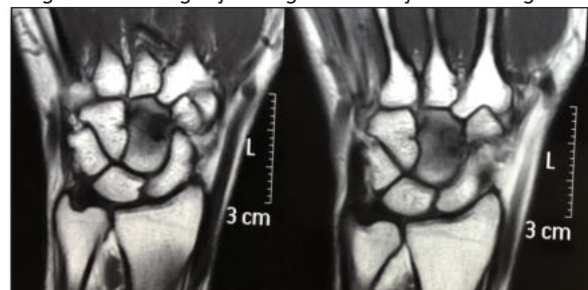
PRE-OPERATIVE T1 WEIGHTED CORONAL MRI SLICE OF THE RIGHT WRIST OF CASE. AT TIME OF DIAGNOSIS. THE DISTAL PART OF THE CAPITATE HAS A LOW INTENSITY SIGNAL.
